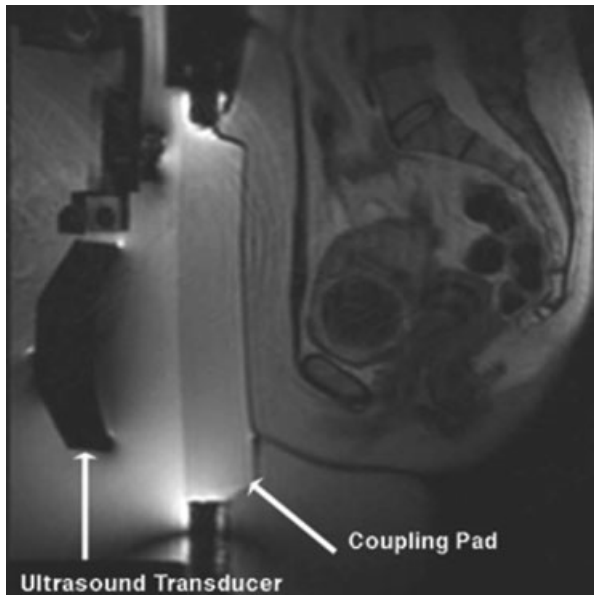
Patient in position on the magnetic resonance-guided focused ultrasound (MRgFUS) table. She is lying in the water bath on top of an acoustic gel pad that allows good contact between the transducer and the body. (Courtesy of InSightec.)
